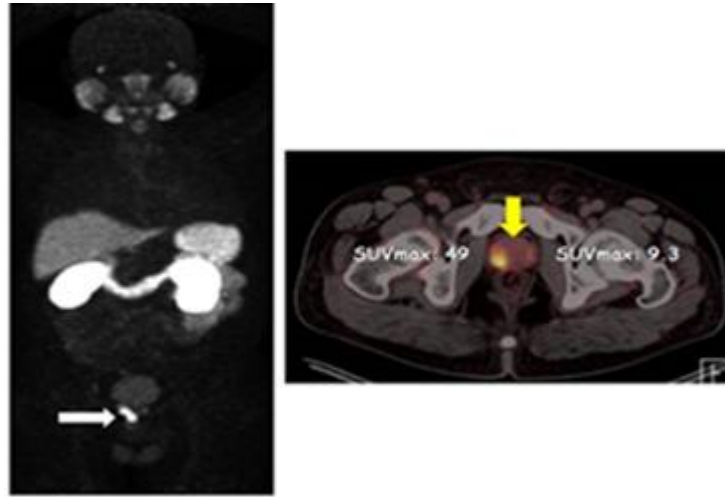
MIP and axial fusion images of a 59 year of Gleason scor 7 (3+4) prostate cancer patient with PSA level 22 demonsrates only primary prostate multifocal Ga-68 PSMA uptake.
